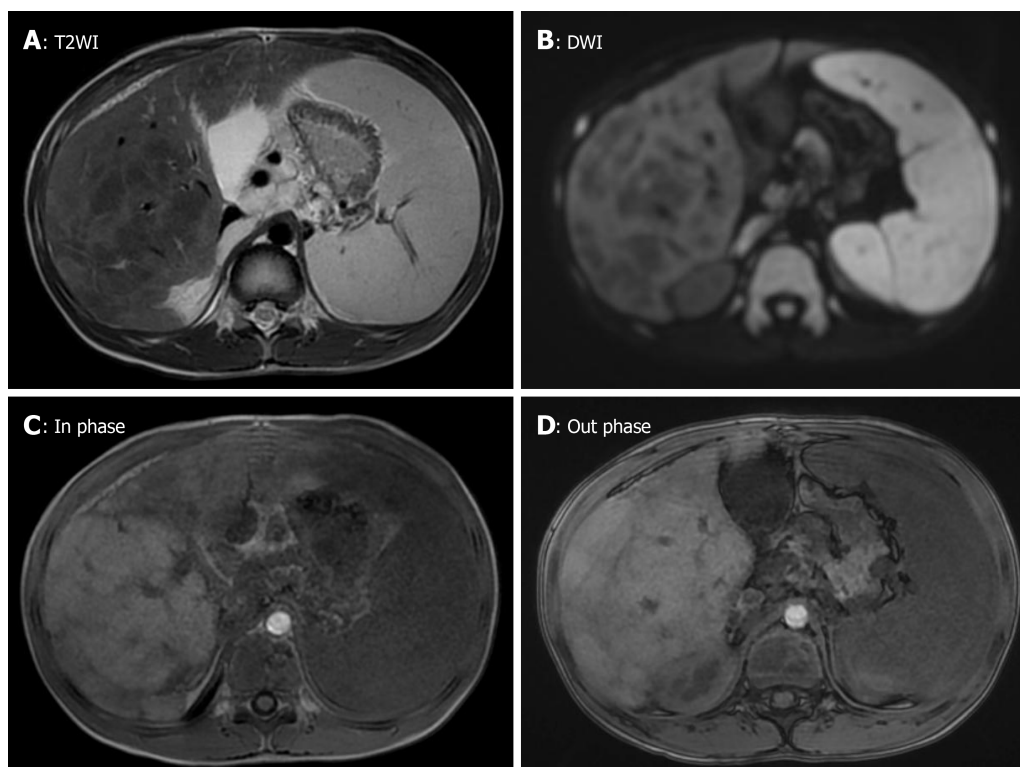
Abdominal enhanced magnetic resonance imaging. A and B: Multiple nodules were observed in the liver; C and D: No washout of the contrast agent in the nodules was detected in the late phase of contrast enhancement.
